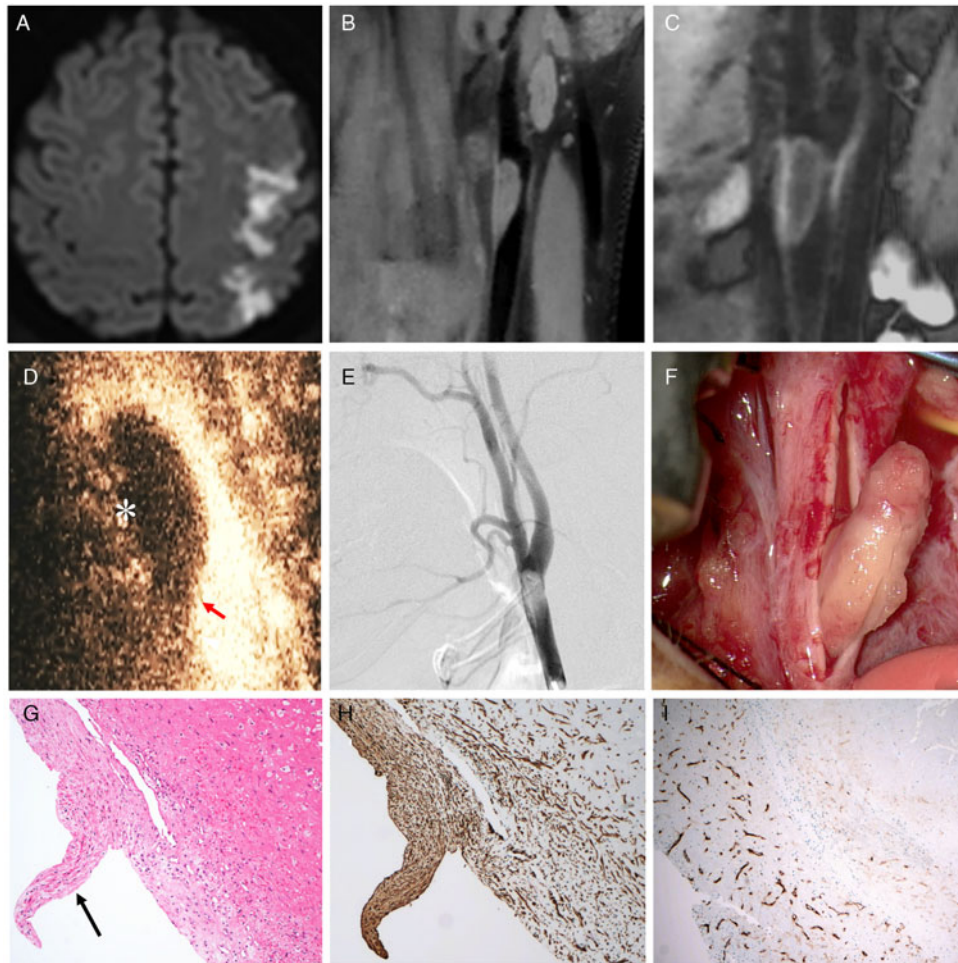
(A). Brain MRI showing acute embolic infarcts in the left frontal lobe. Isointense (B) and linear surface enhancement (C) mass in the left common carotid artery (arrow) on coronal HR-MR. (D) Contrast-enhanced ultrasound (CEUS) image of the carotid mass, microbubbles could enter between the mass and the carotid vessel wall (asterisk), and the mass was tightly attached to the intima of the vessel wall (red arrow). (E) Digital subtraction angiography showed severe stenosis of the common carotid artery with regular filling defects (arrow). (F) Intraoperatively, the mass was found to be attached to the intima only at the proximal end. Pathologic examination of the mass. (G) showed a large number of fibrin threads, capillaries, scattered red blood cells, and leukocytes with nuclear disintegration. Note the early organization with the growth of fibroblasts (SMA (+)) and capillaries (CD34 (+)) (H and I, respectively). Fibrous stripe-like structures are attached to the intima (see arrow).
